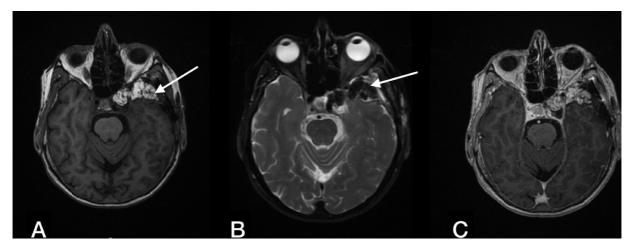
2nd day postoperative axial T1-weighted (A), T2-weighted (B), and T1-weighted with contrast enhancement (C) MRIs show gross total resection of the tumor. Note the T1 hyperintense and T2 hypointense signal (*arrows*) of the fat graft that was placed at the end of the resection.
